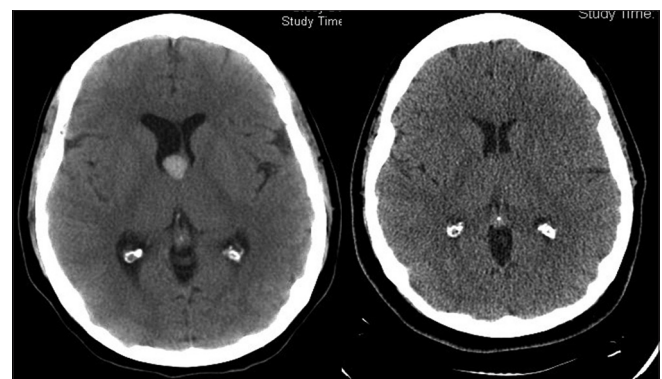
Radiologic images of patient #3. Left: Discovery MR image showing a mass within the anterior third ventricle at the foramen of Monro representative of a colloid cyst. Right: 6-week post-stereotactic aspiration and pre-stereotactic radiosurgery planning T1-weighted MRI demonstrating reduction in ventricle size as well as indicating that the colloid cyst is no longer identified by the imaging study
